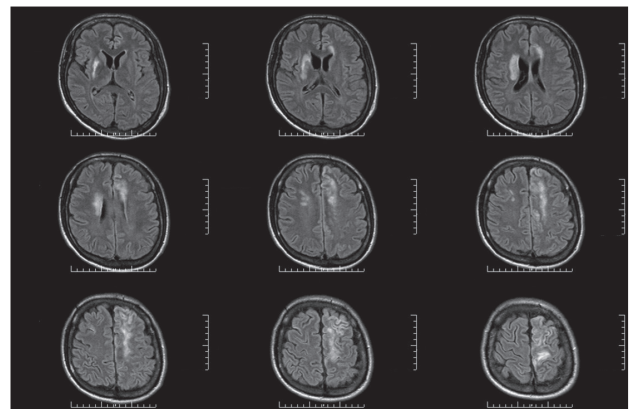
Axial FLAIR weighted MRI shows multiple areas of ischemia, affecting the territory of small vessels in the cortical, subcortical and basal ganglia area.
